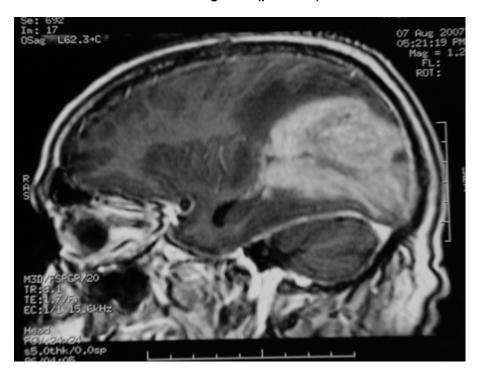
MRI (Sagital) T1weighted after Gadolinium injection: Brain involvement in the occipital area (patient 3)
